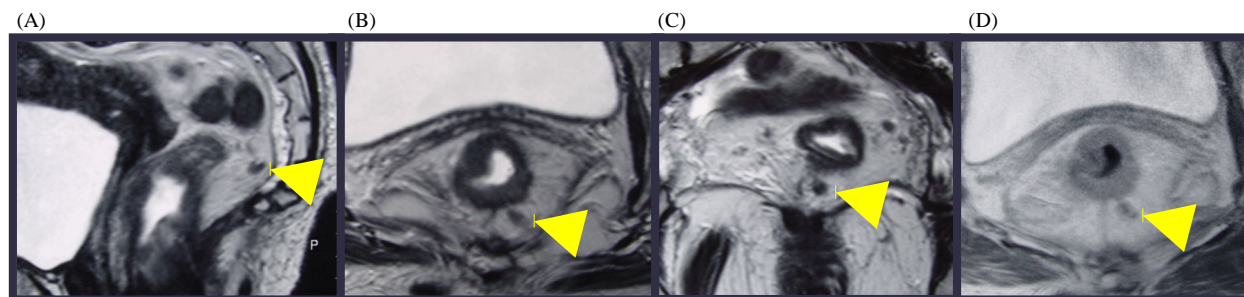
A 70-year-old man with T3 rectal cancer. T2 weighted sagittal (A), axial (B) and coronal (C) images show only 7mm-sized perirectal LN, however showing irregularly spiculated border and mottled signal intensity (arrows). On cadolinium-enhanced T1-weighted axial image (D), that LN show heterogeneous enhancement with indistinct margin. Both review predicted positive perirectal LN status, and that was correct.
